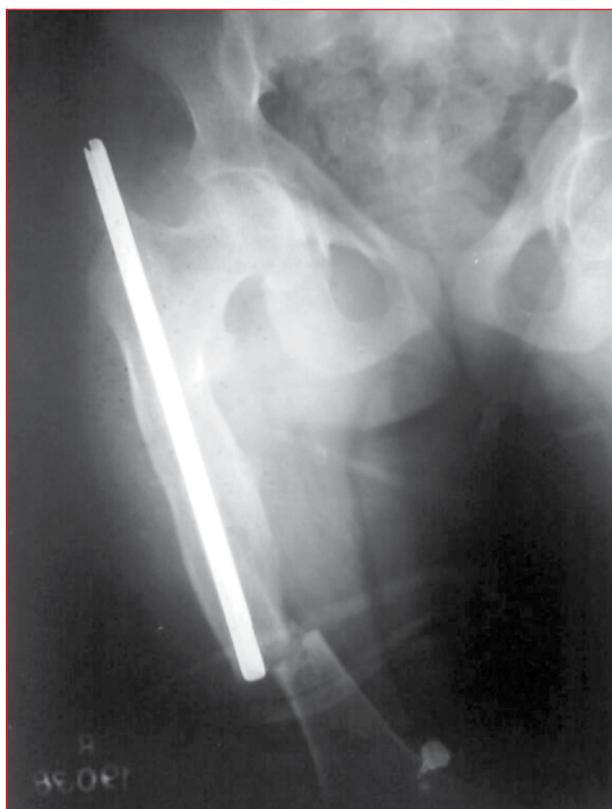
An X-ray showing a previous intramedullary nail in situ and the fractured femur
